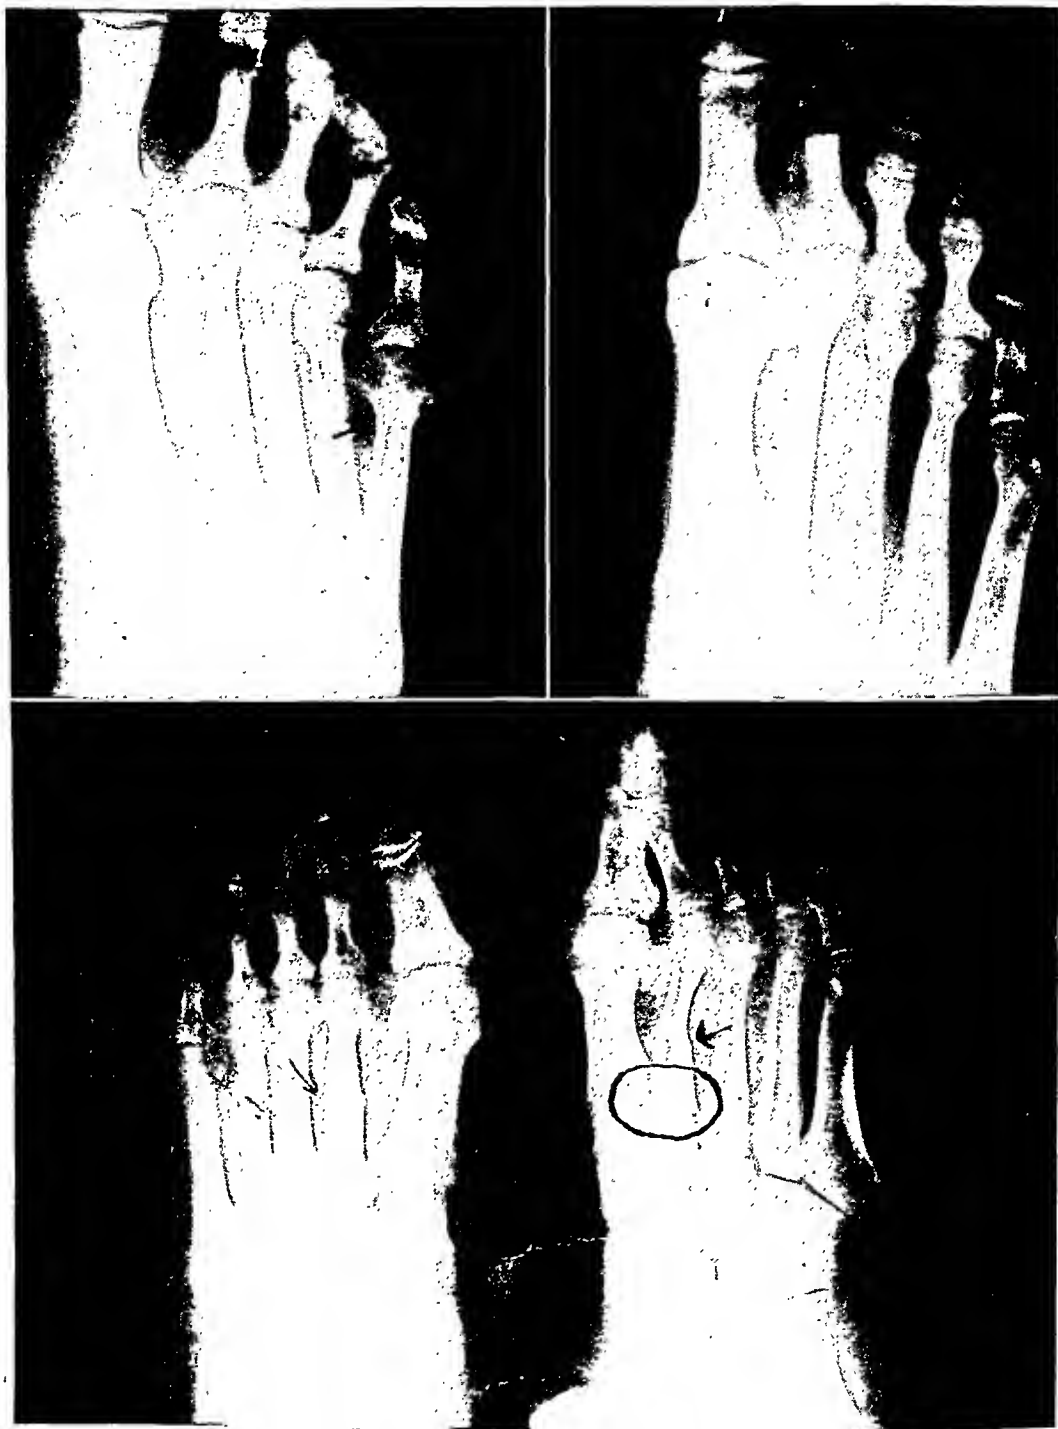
Case 14: Old, healed, previously unrecognized fracture of distal shaft of little toe metatarsal bone. The patient recently dropped a casting on the foot; recalled stubbing little toe twelve years earlier. No x-ray examination then.
